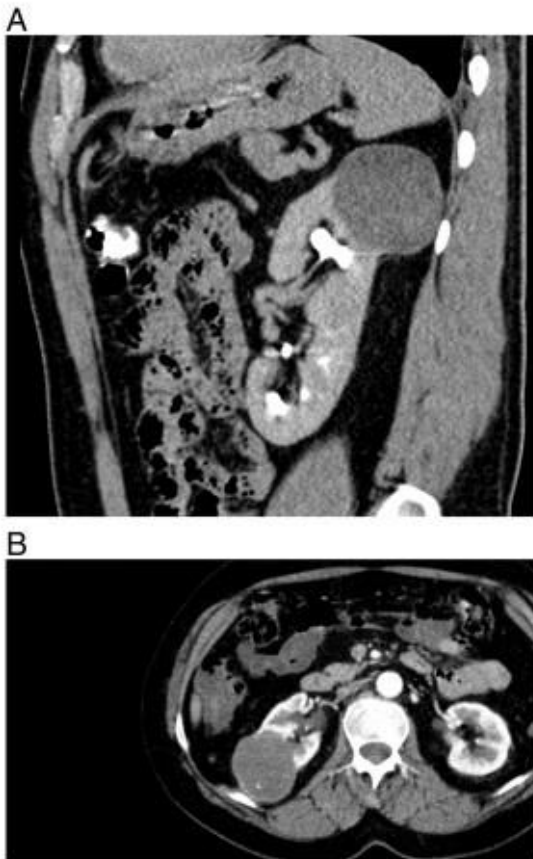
(A) Case 2. Postcontrast computed tomography (CT), excretory phase, sagittal section. A round-shape tumor of the upper pole of the left kidney. Postcontrast density 17–61 HU. Necrotic center of the tumor is clearly visible. (B) Case 3. Postcontrast CT, arterial phase, axial section. Tumor of the right kidney, round shape with large central necrosis, postcontrast density 25–68 HU.
